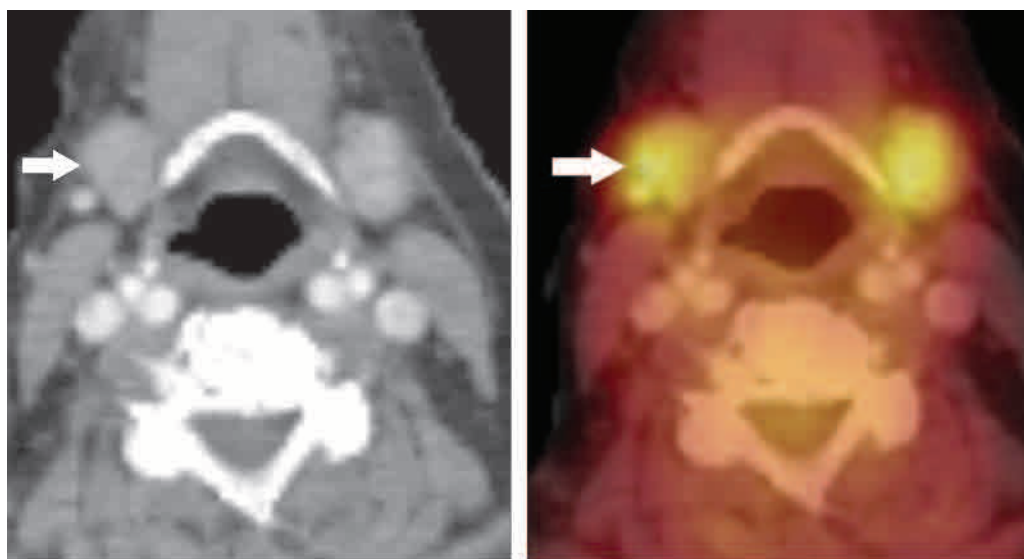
Physiologic submandibular uptake. Axial CT (a) and fused PET-CT (b) scans demonstrate symmetric FDG uptake that is localized to the submandibular glands (arrow).
